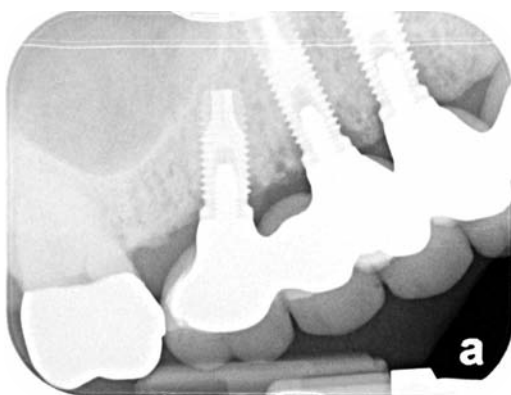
Radiograph showing a full contour zirconia based restoration on the upper right second molar. This shows the radiopacity of the restoration blocking out any underlying tooth structure.
